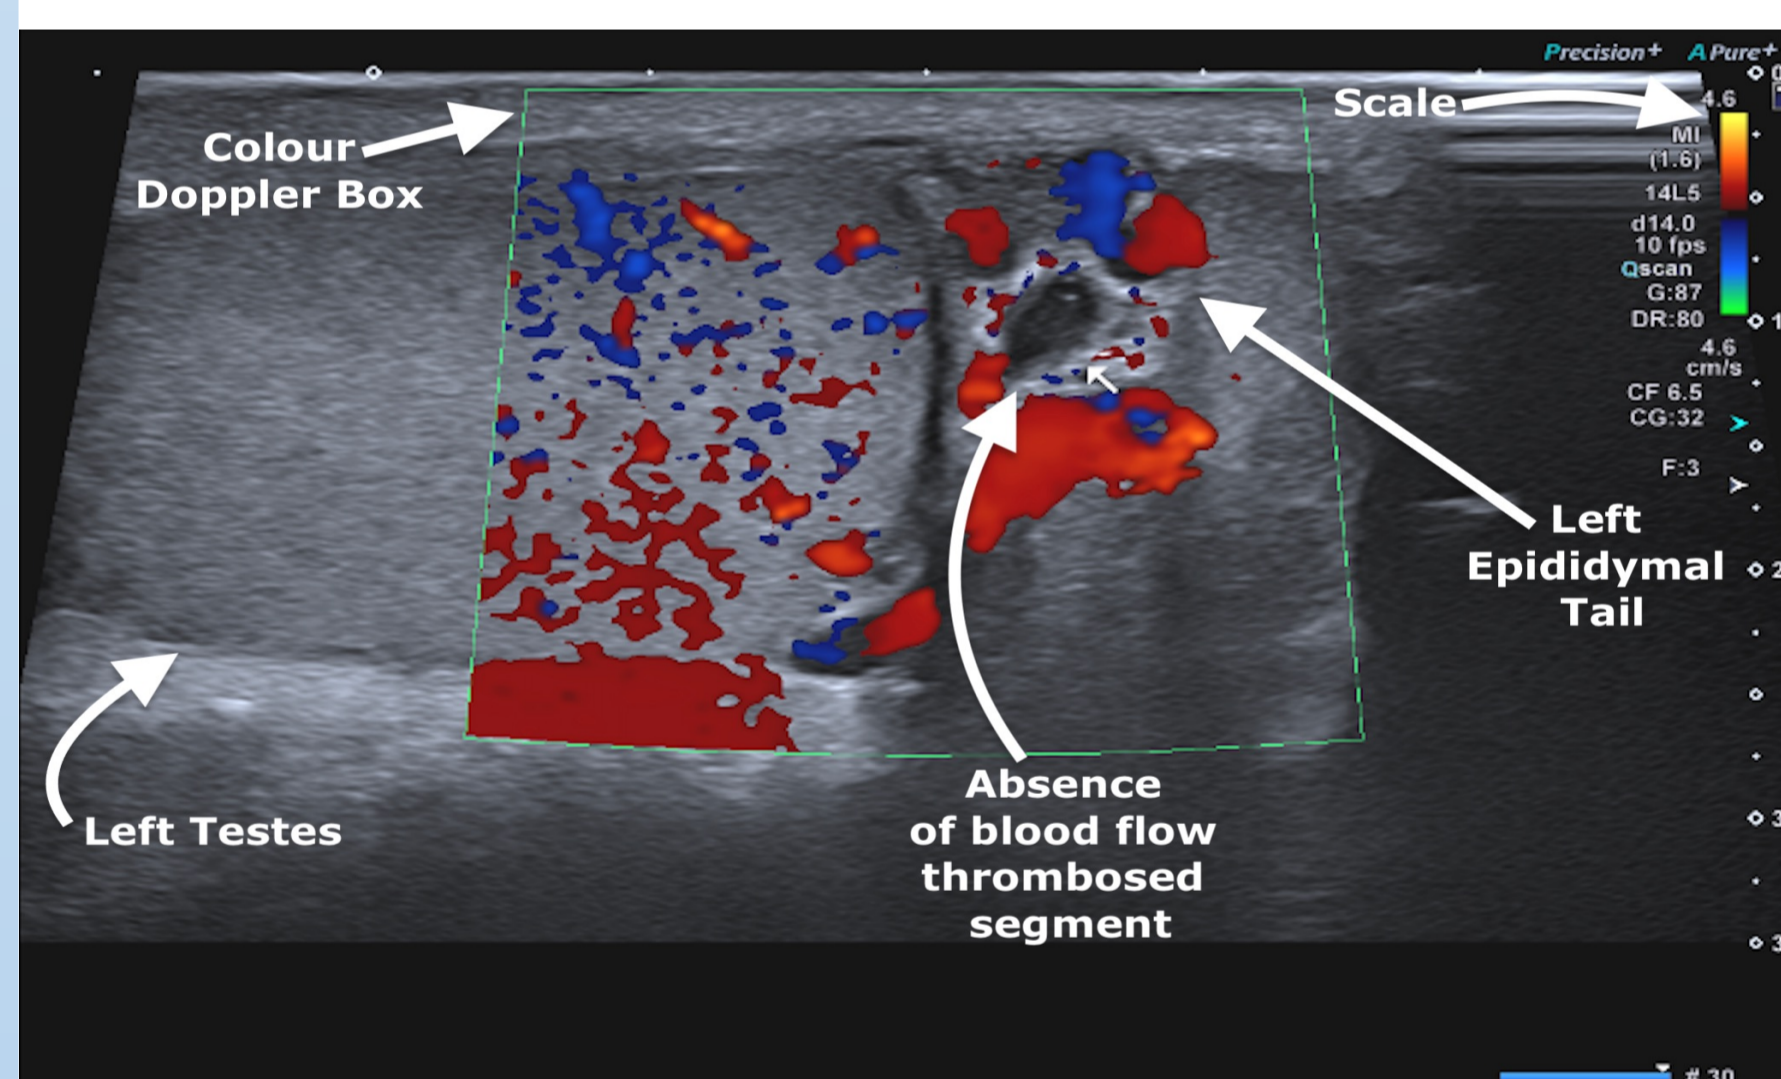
Colour doppler of the left testes and epididymal tail, highlighting normal vascularity in the left testes and a small hypoechoic tubular structure with no vascularity, located within the varicocele (Hospital X, 2023).
